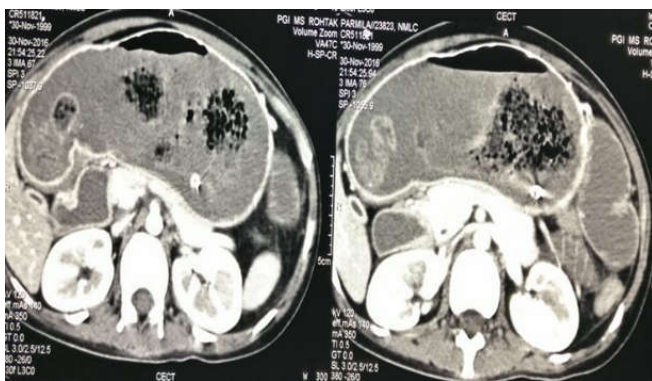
CT scan of the same patient shows intragastric and ileal contents showing Characteristic mottled appearance with small bowel obstruction.
